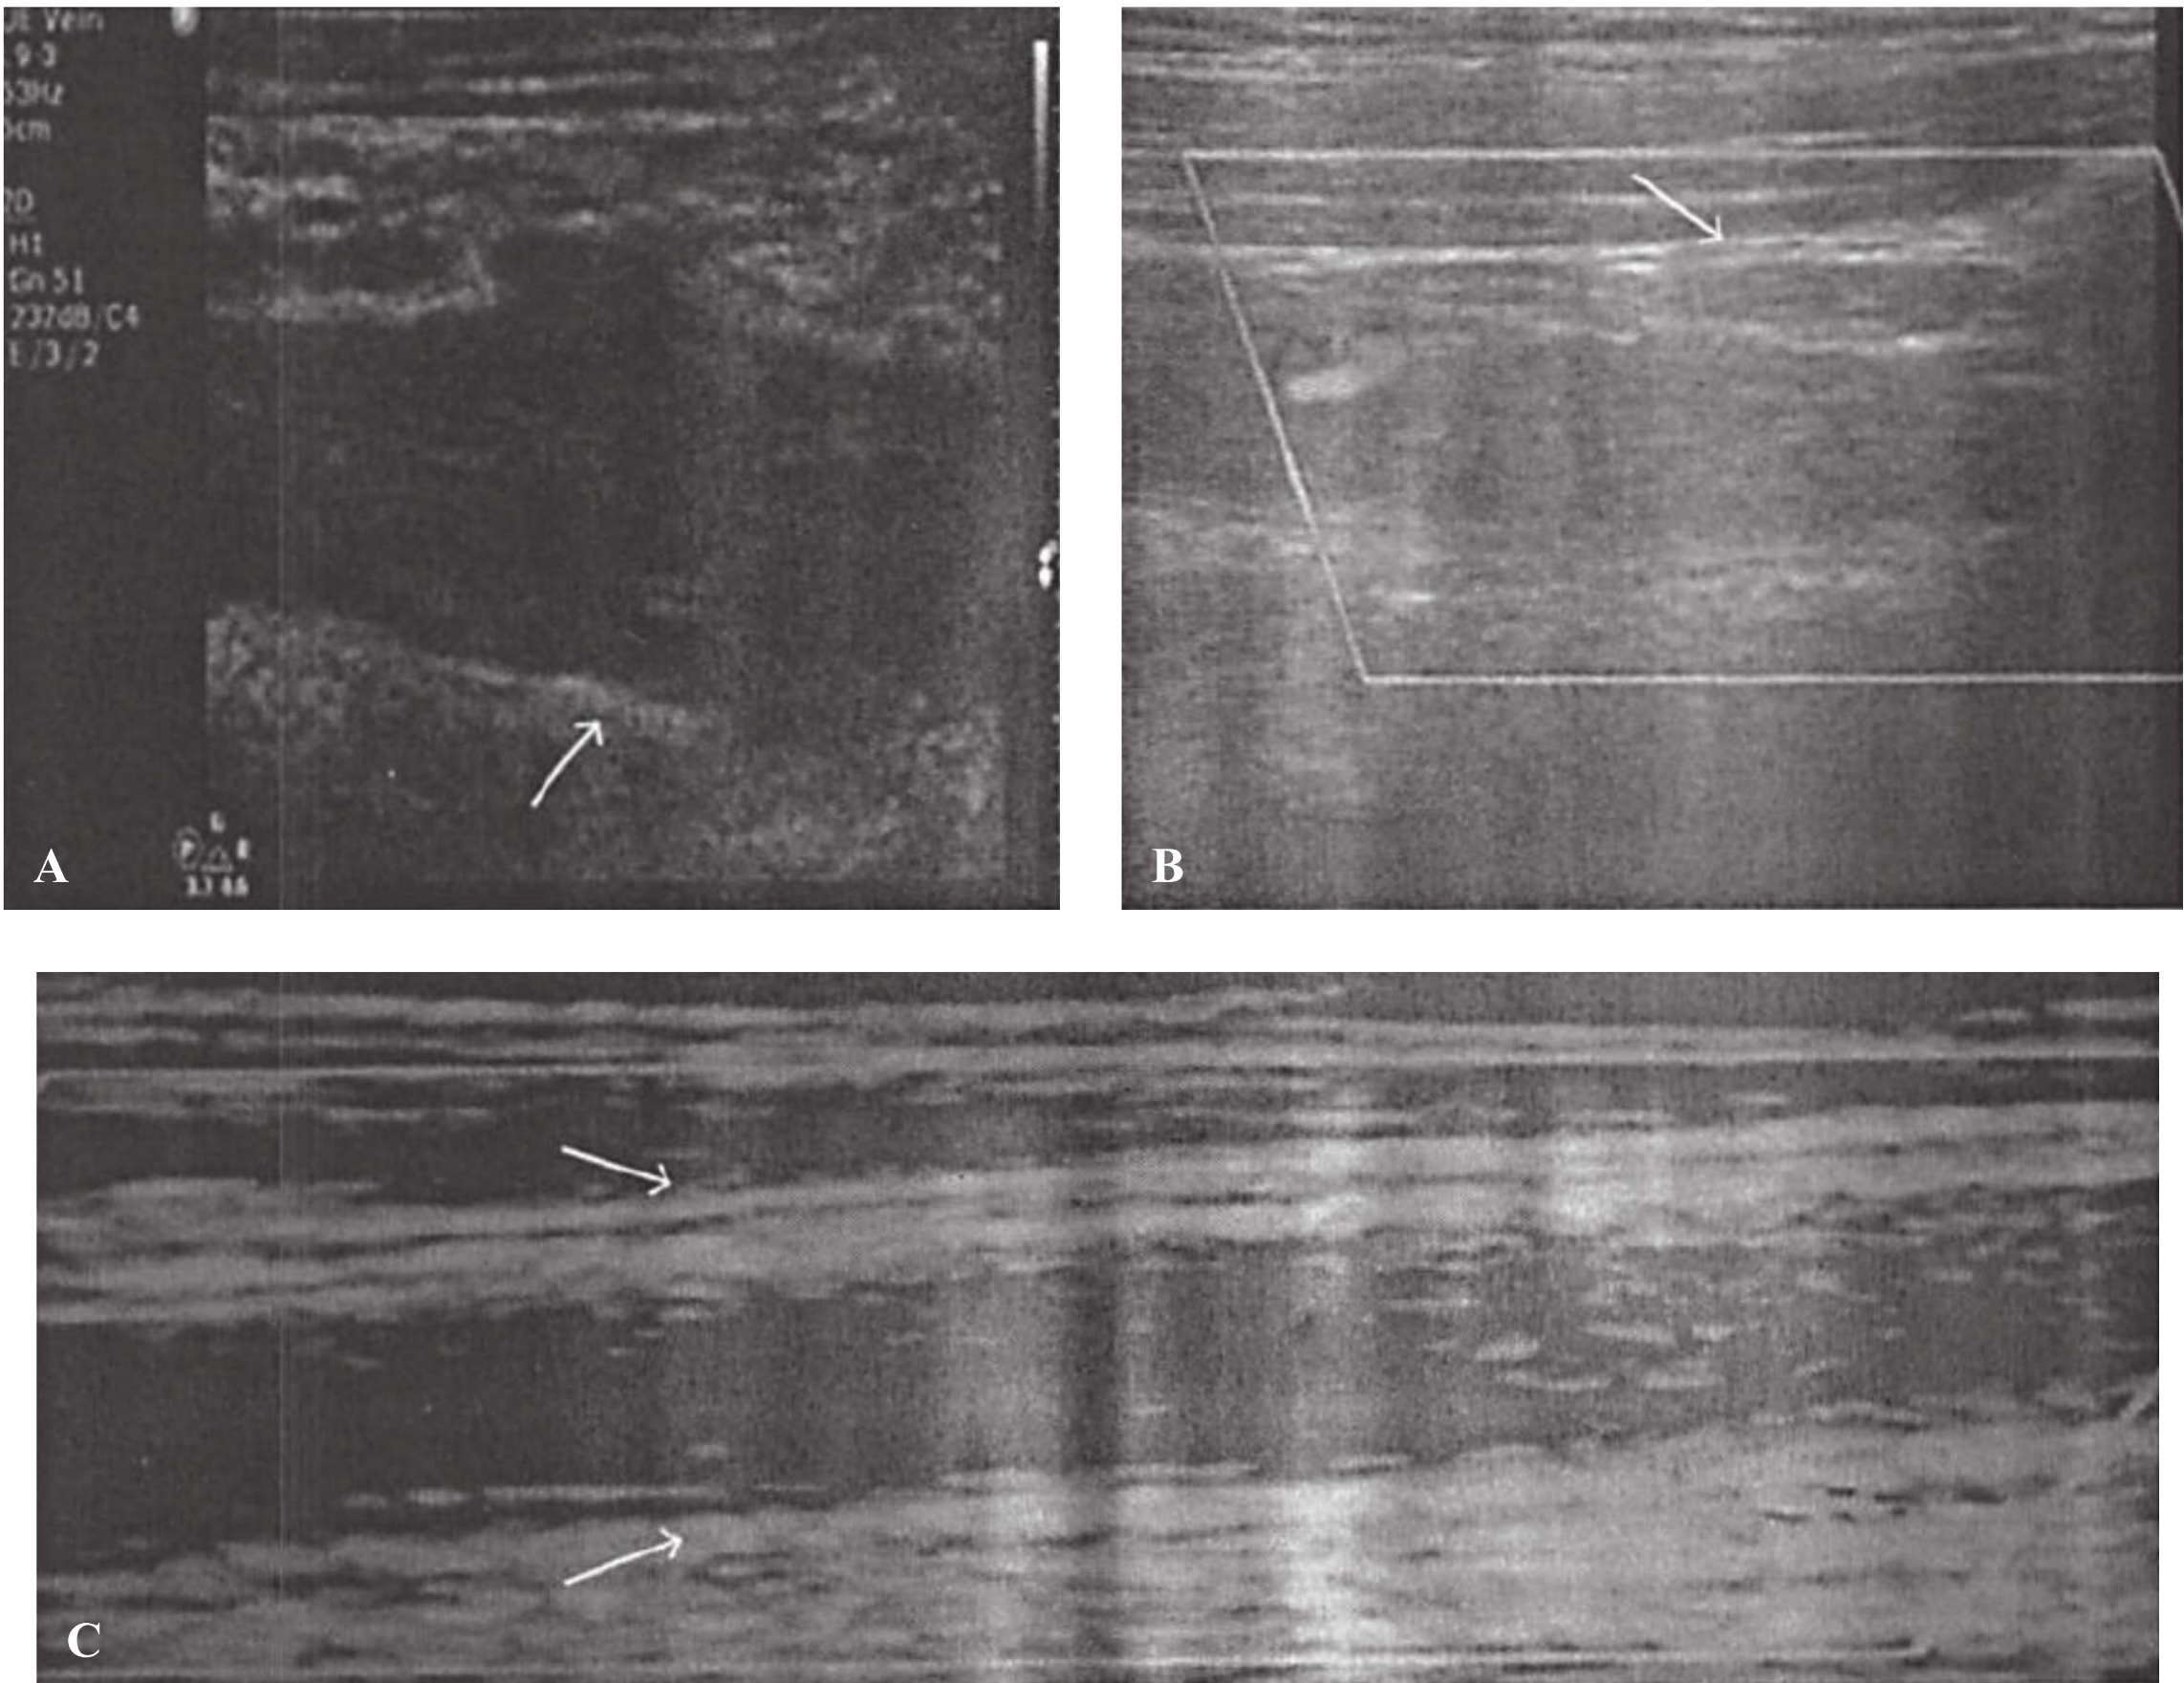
Double hyperechoic line along fresh thrombus/wall interface (*arrows*) of the subclavian veins (A and B) and in extended segments of the left brachial vein (panoramic view with zoom) (C). Reproduced with permission from Blaivas M, Stefanidis K, Nanas S, et al. Sonographic and clinical features of upper extremity deep venous thrombosis in critical care patients, *Crit Care Res Pract*. 2012;2012:489135.
